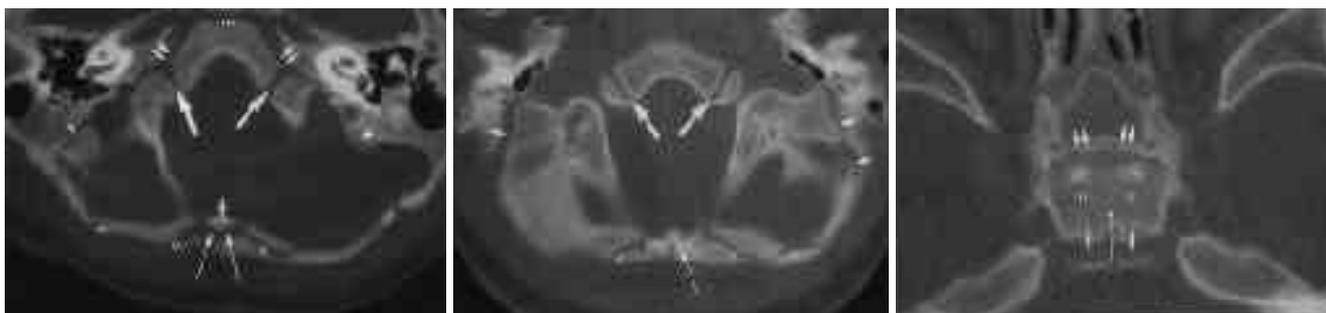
Axial CT scan of the occipital bone in a 5-month-old female infant. All sutures and synchondroses are widely open, including Kerckring-supraoccipital synchondrosis (long arrows), exoccipital-supraoccipital synchondrosis (double arrows), occipitomastoid suture (arrowheads), basioccipital-exoccipital synchondrosis (large arrows), petro-occipital synchondrosis (double arrows), and sphenoccipital synchondrosis (triple arrows). Note the Kerckring ossicle (single arrow) located in the middle of the posterior aspect of the foramen magnum.
